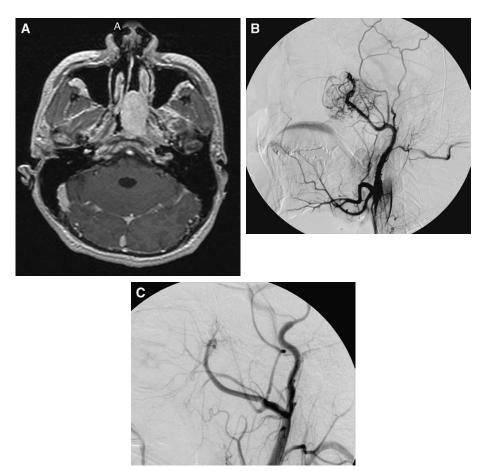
(A) Axial MRI shows a 27-year-old man with a large juvenile nasopharyngeal angiofibroma. (B) The distal branches of the internal maxillary artery luxuriously supply the tumor. (C) Postembolization angiogram shows no residual arterial supply to this hypervascular tumor.
